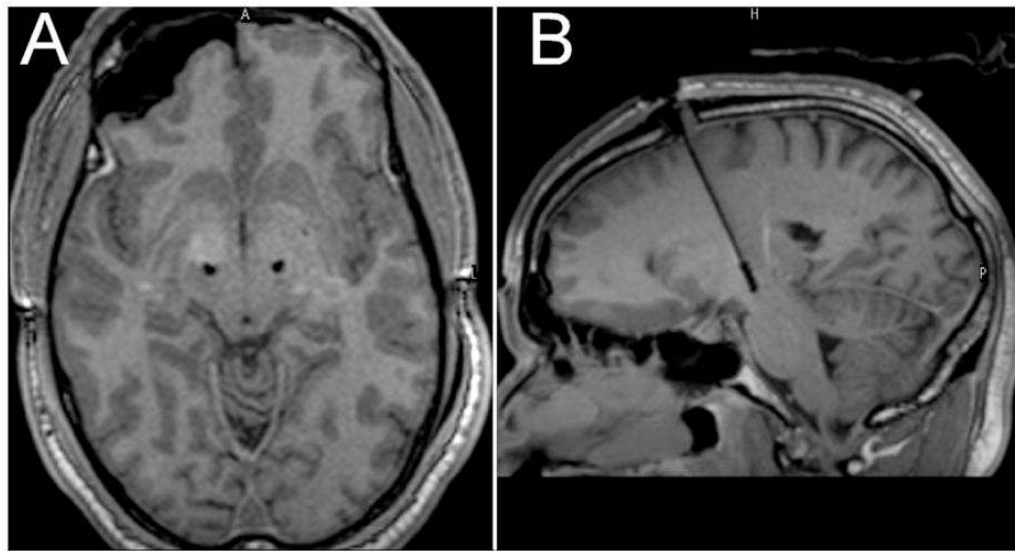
Final lead location as assessed on T1-weighted volumetric MR images. A: Axial image at 4 mm inferior to the commissures. B: Reformatted oblique image in the sagittal plane along the lead trajectory (MR protocol 8).
